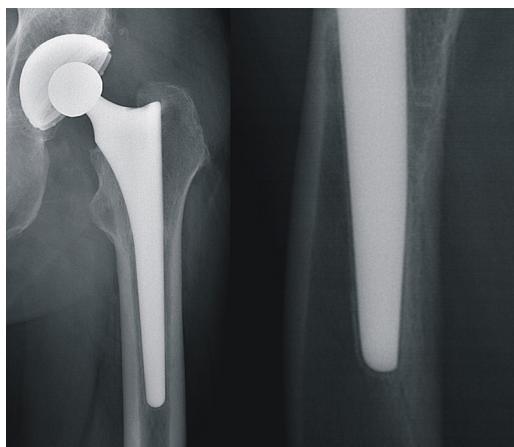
X-rays showing reactive lines in Gruen zone 2 up to and including zone 6 (AP view, left), and zone 9 up to and including zone 13 (lateral view, right) around a Symax™ stem. This is a sign of absence of bone attachment in the distal anodized part of the stem.
